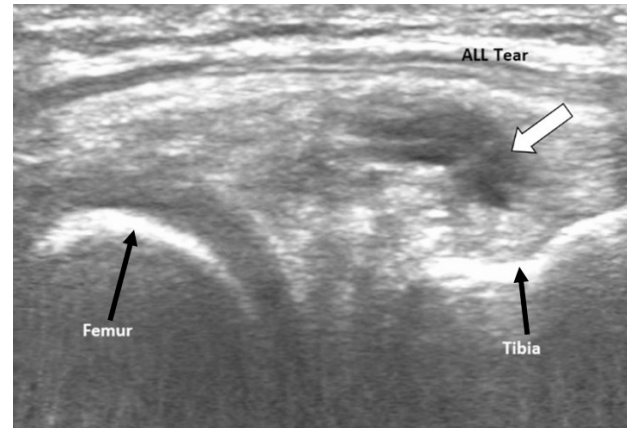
ALL and anterolateral meniscocapsular tears on ultrasound before PRP injection
